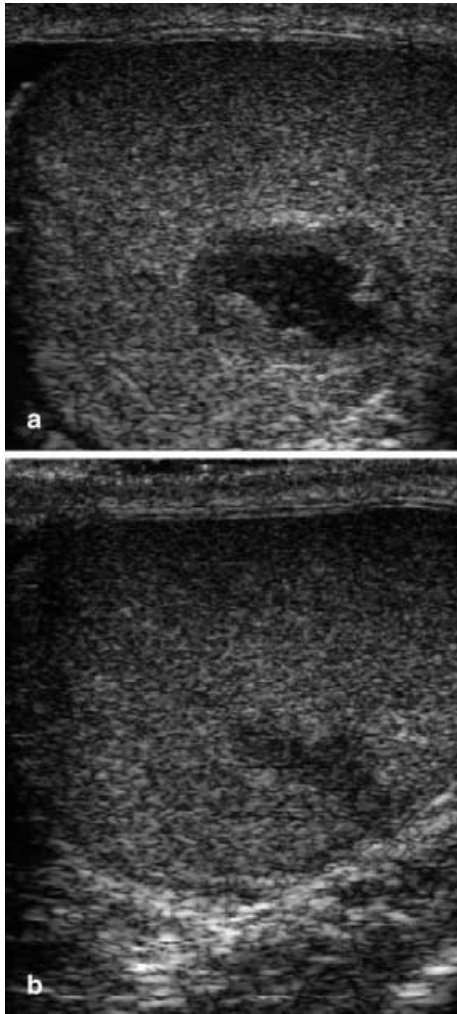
Testicular hematoma. a Intratesticular hematoma a few days after a mild scrotal trauma and b confirmed at MRI almost completely resolved 6 weeks later
